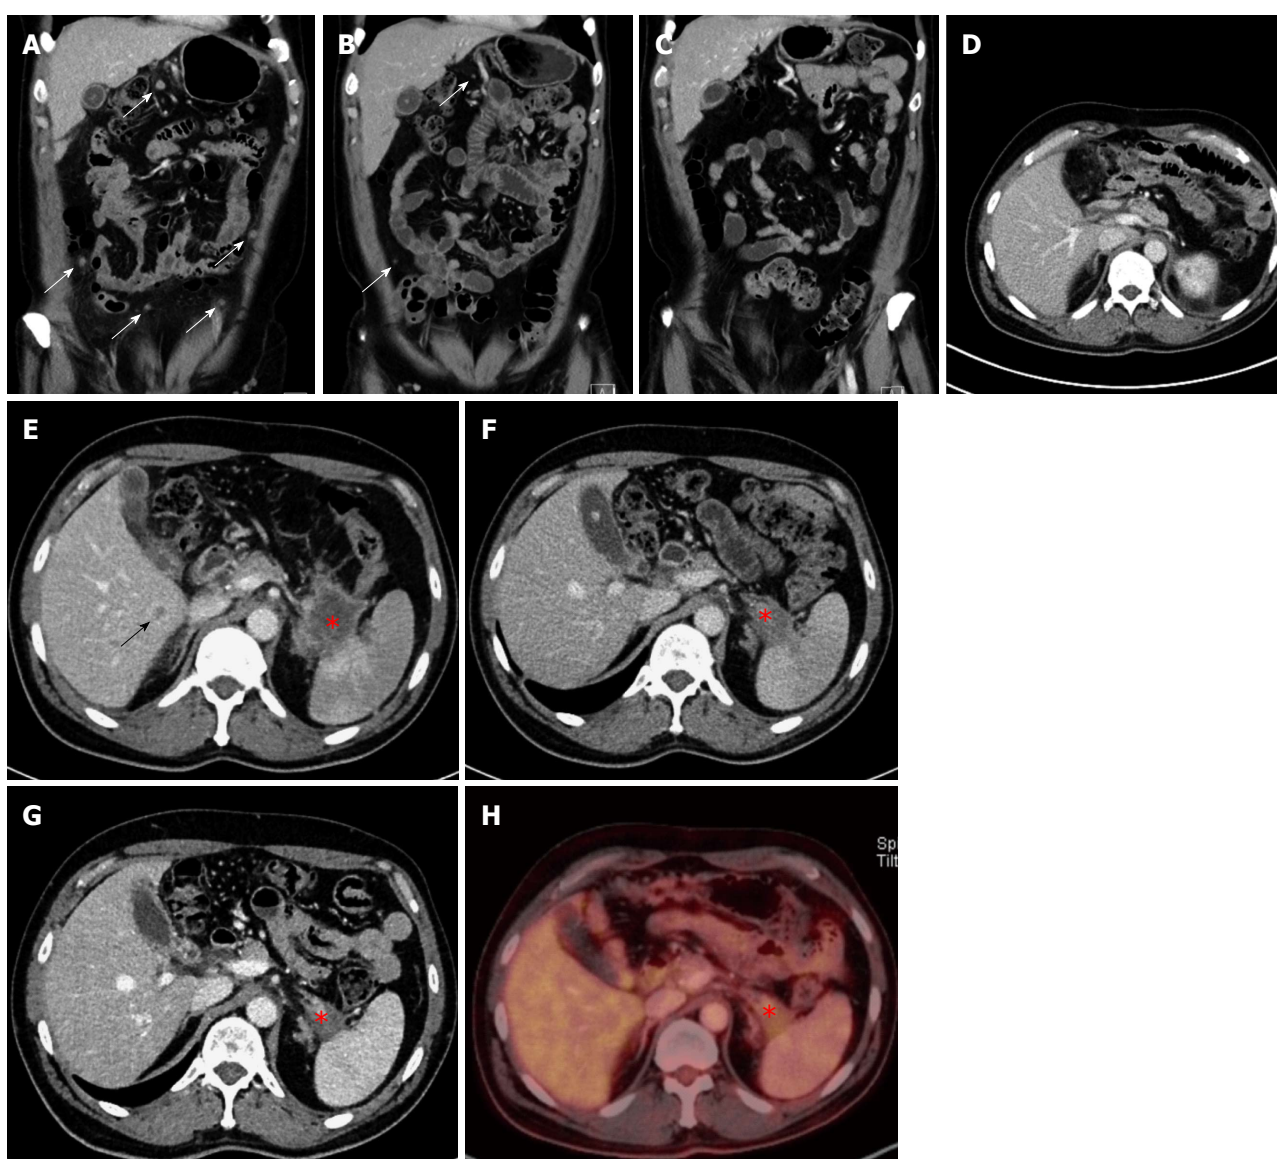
Computed tomography and positron emission tomography images of patient 2. Coronal (A, B, C) contrast-enhanced CT images demonstrated complete regression of multiple peritoneal metastases (white arrow). Axial CT images (E, F, G) and PET-CT image (H) show a regredient mass (star) in the tail of the pancreas. Liver metastasis (black arrow) was seen only in the initial CT-examination (E). Post-operative CT (D) showed complete resection of the primary tumor in the pancreatic tail and no visible metastases. CT: Computed tomography; PET: Positron emission tomography.
